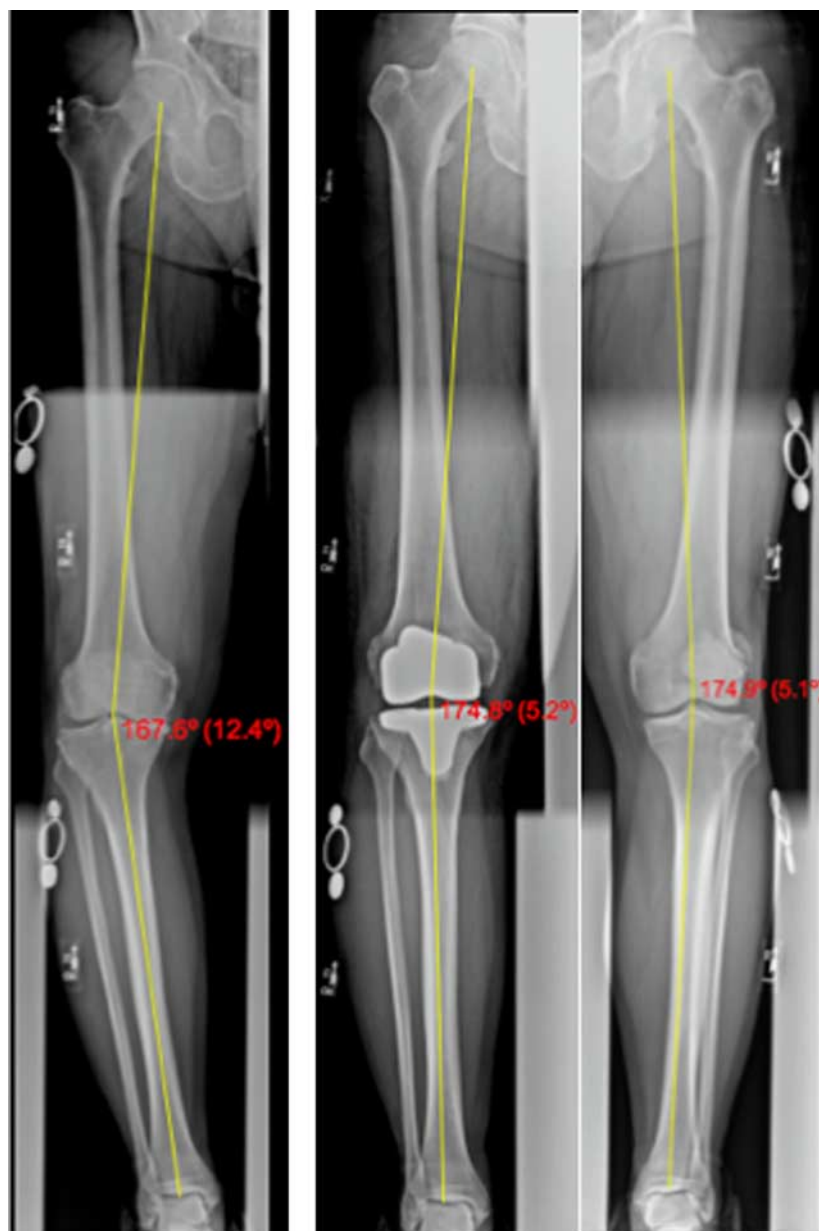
A preoperative long-leg radiograph showing a hip, knee, ankle angle of 12 degrees of varus. Postoperative imaging shows that the new limb alignment using the linked and tensioned extramedullary resections (LATER) technique for total knee arthroplasty has brought the limb back to the same alignment of the nonarthritic knee, 5 degrees of varus. Level of improvement: 4; patient satisfaction: 6.
